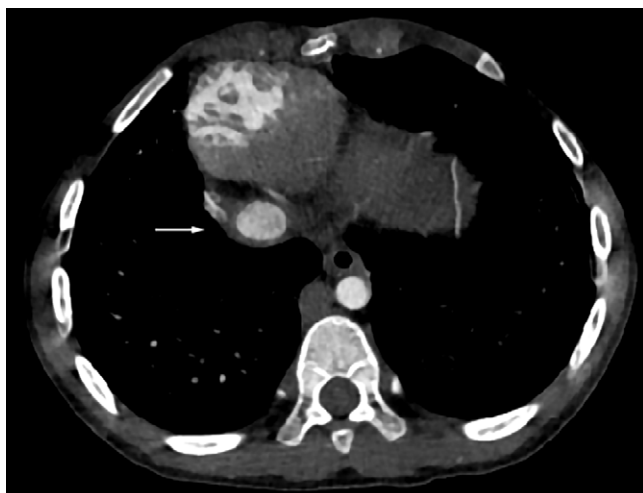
Pre-operative CT scan showing the hepatic vein (arrow) drained directly into the atrium, the enlarged azygos vein parallel to the aorta.
